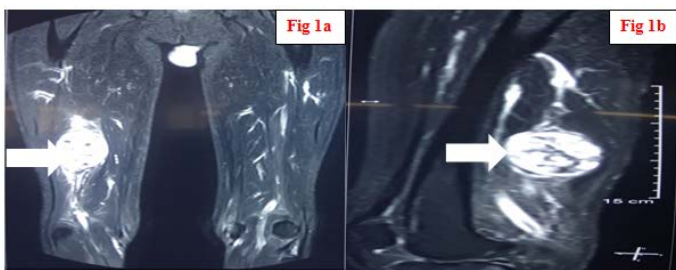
a and b: Magnetic Resonance Imaging showing about 6.1*5.1*4.4 cm lesion in intermuscular plane seen
